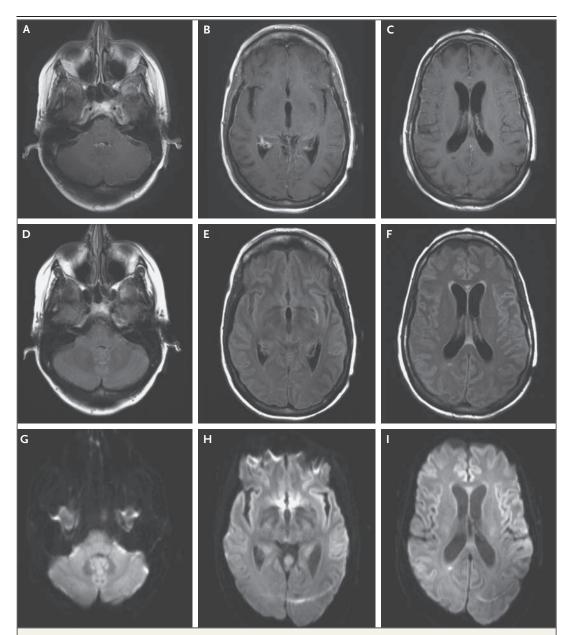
Initial MRI of the Head.
